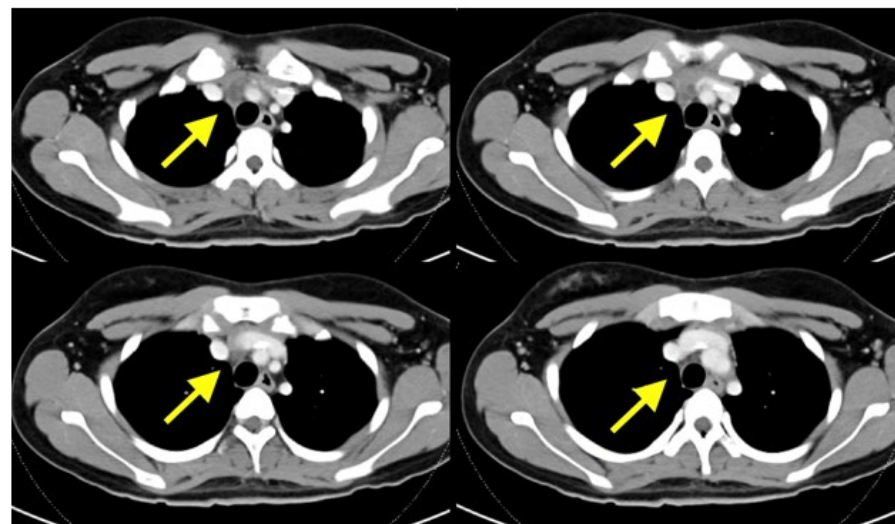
CT thorax showing 2 focal lesion in anterior mediastinum, with heterogeneous multicystic appearance, and closely related to bilateral sternoclavicular joint
